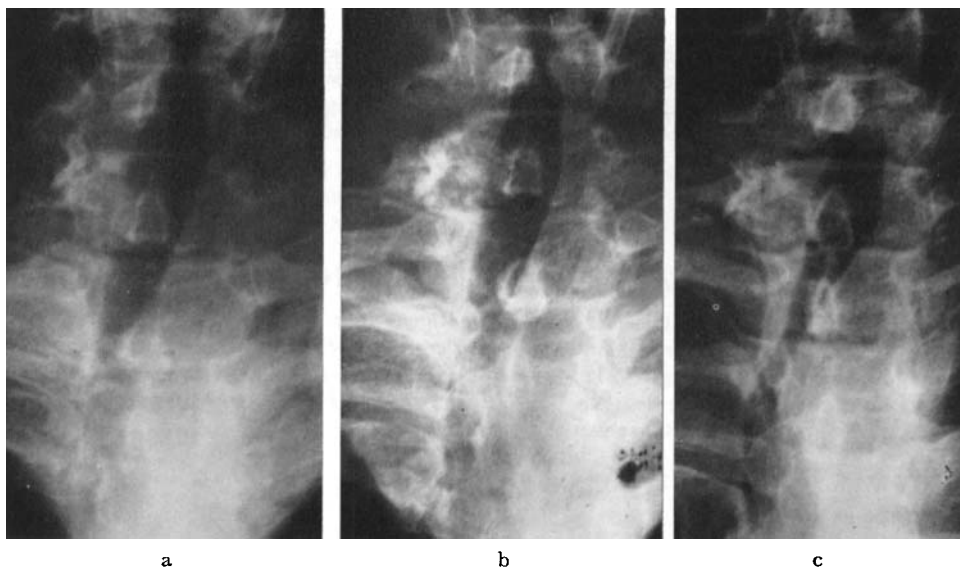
Investigation one year after ^{131}I therapy. Roentgenograms: a) during normal breathing, b) during Valsalva's maneuver, c) during Müller's maneuver.
